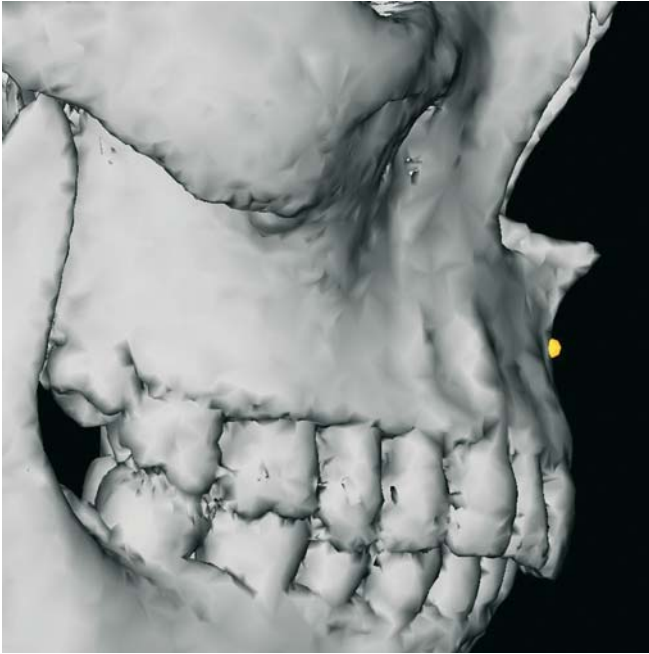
A-Point. Profile view right (3-D CT, patient K.C.)
